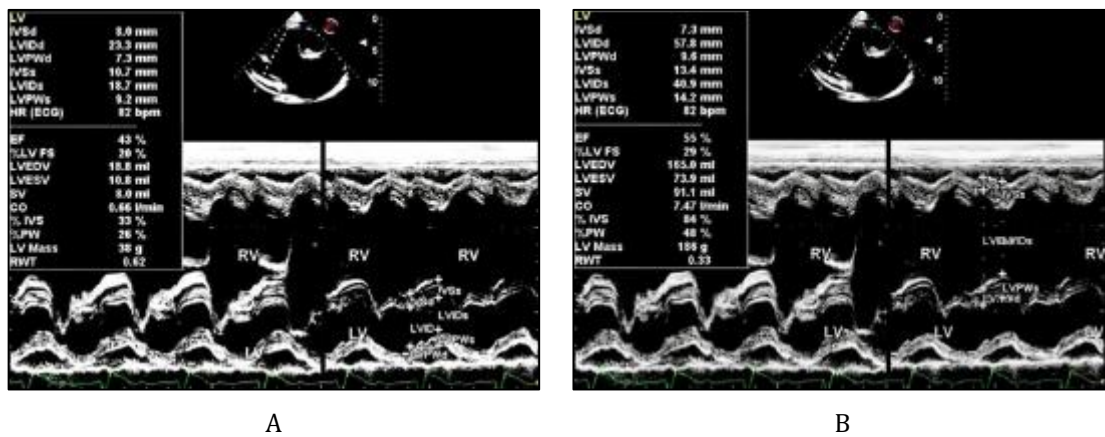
M-mode Echocardiography. (A) LV and (B) RV, M-mode measurements
